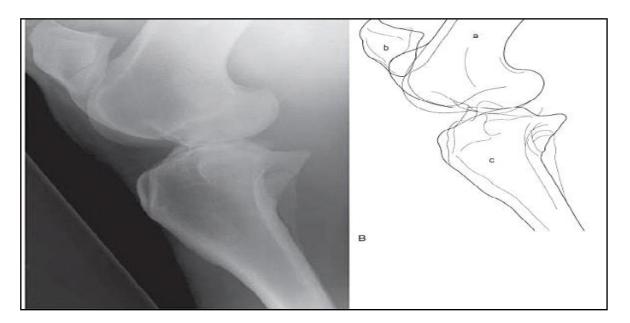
Lateral radiograph of the stifle a- femur, b- patella, c-tibia
